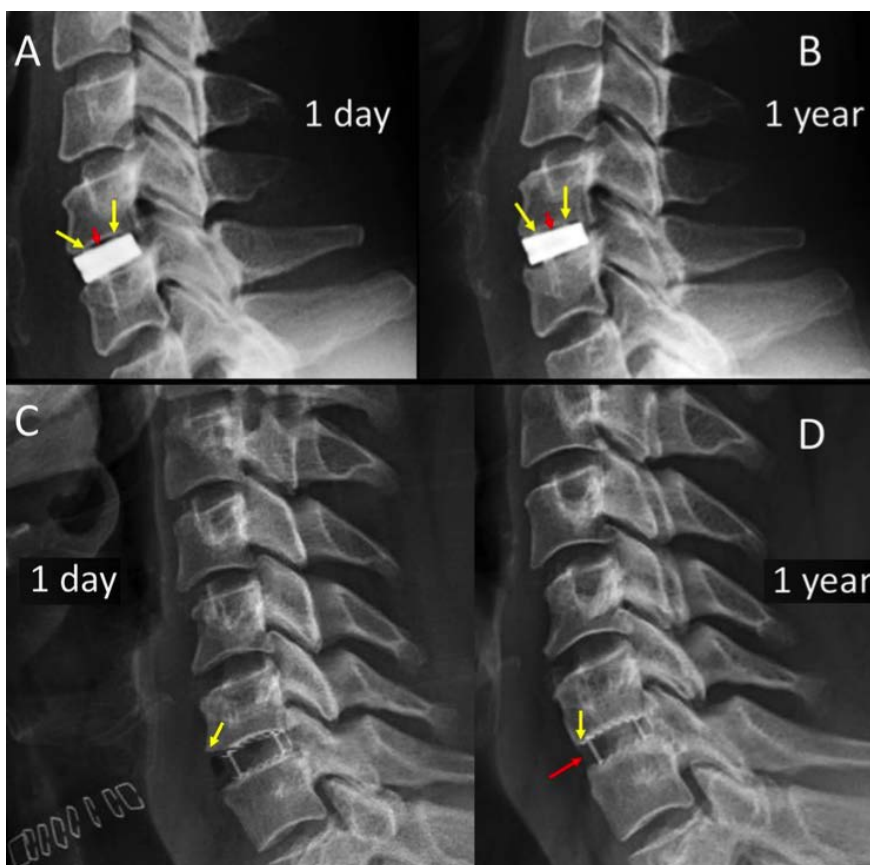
Comparison of mediolateral x-rays of a full titanium (A and B) and a titanium porous coated primary stabilization system (C and D). Note the void space (red arrow) at the vertebral-implant interface (red arrows in A and B) for the full TTN cage. In C and D, a complete implant-plate adhesion is visible directly postoperatively and after one year of follow-up. Yellow arrows in C and D depict a squaring modification of anterior-inferior vertebral body angle. Red arrow points to a subtle ossification of the anterior longitudinal ligament (ALL). Both features reveal a beginning degree of secondary stabilization (fusion).
